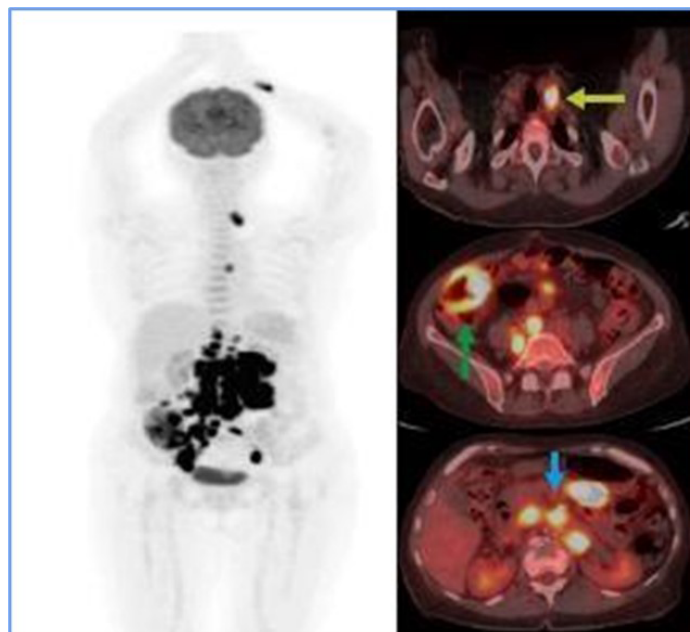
Initial PET CT. Hypermetabolic supra (yellow arrow) and infra diaphragmatic (blue arrow) adenopathy suggest tumor glycolytic activity. Diffuse mural thickening of the hypermetabolic ascending colon (green arrow) in the clinical context of suspected lymphoproliferative disease suggests extranodal involvement.
